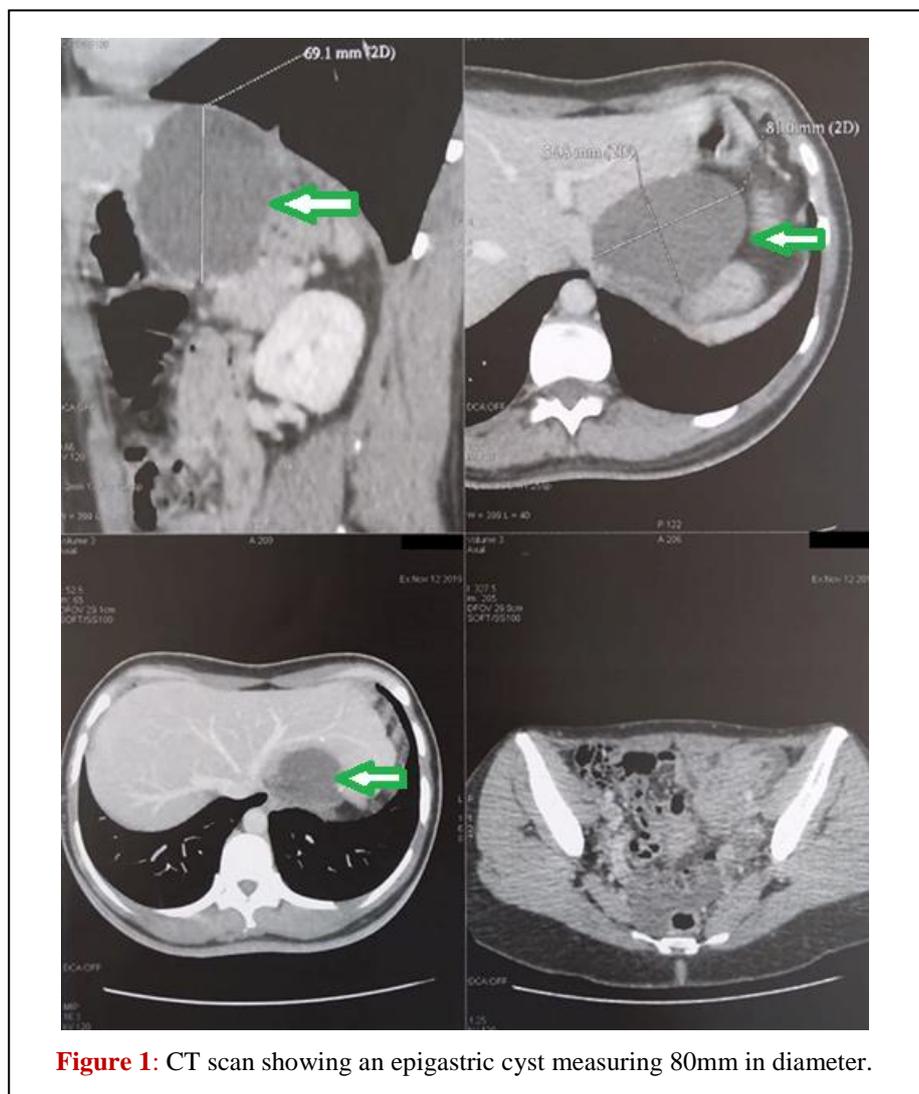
CT scan showing an epigastric cyst measuring 80mm in diameter.
